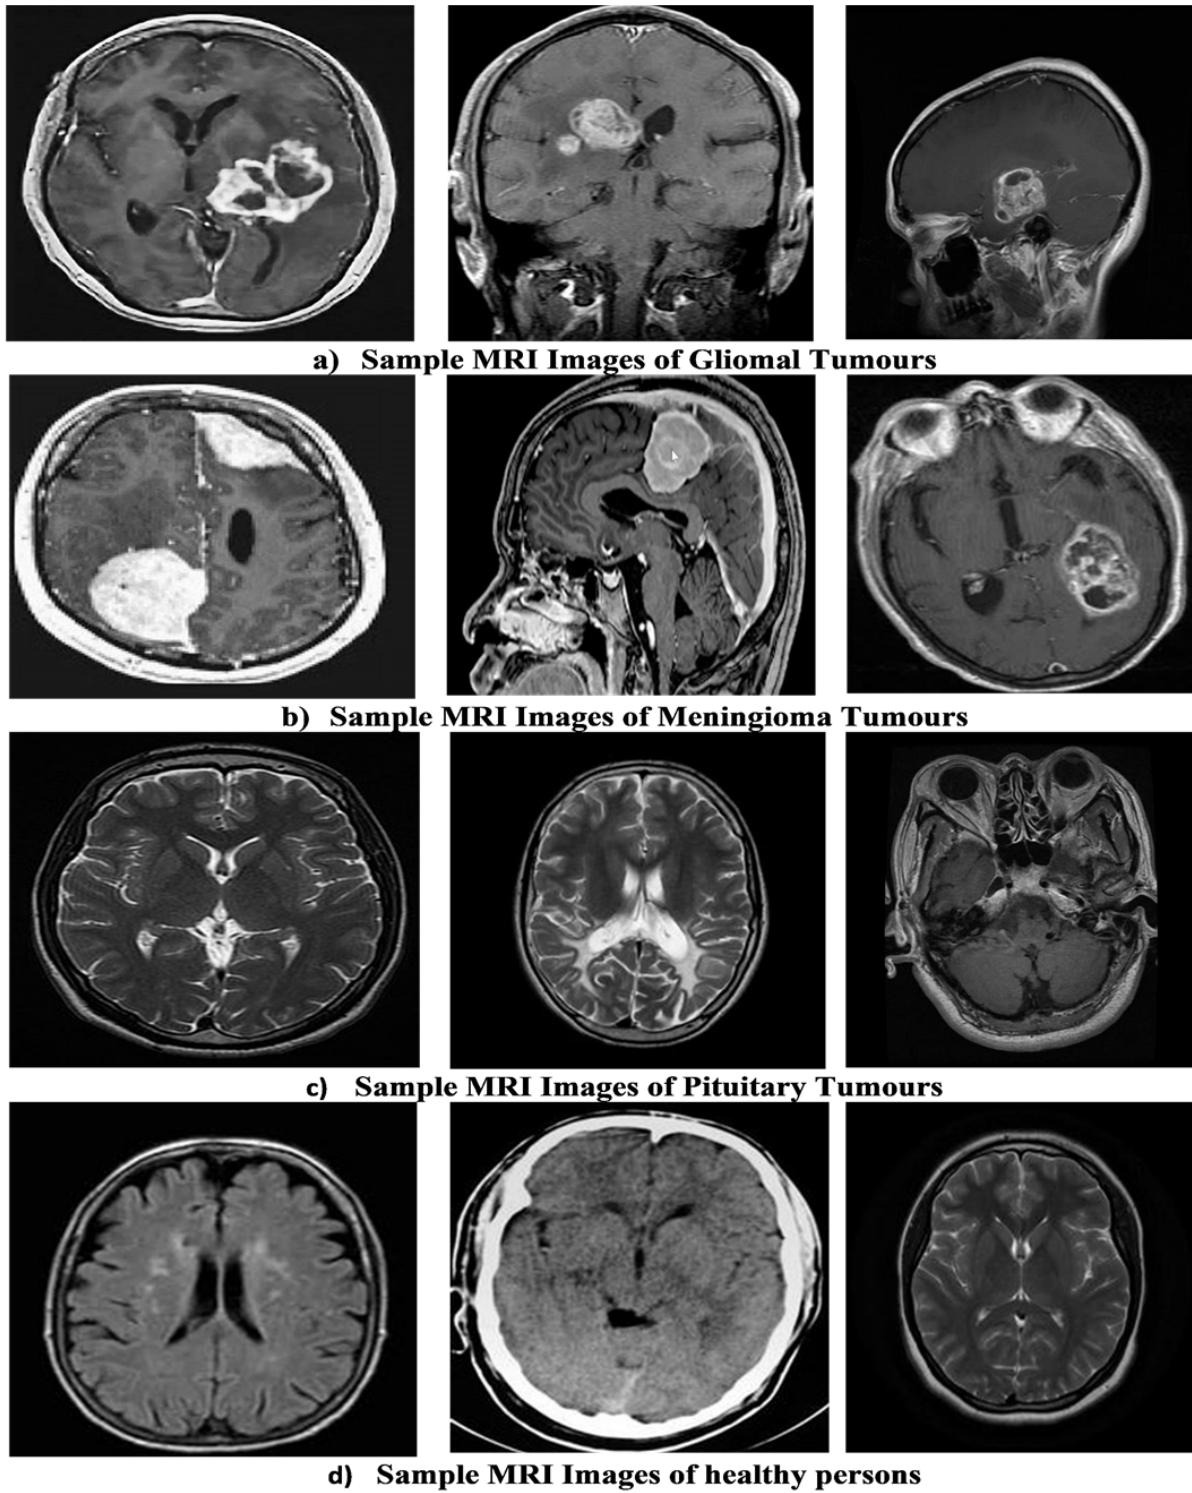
Brain MRI images used for detection and classification.
